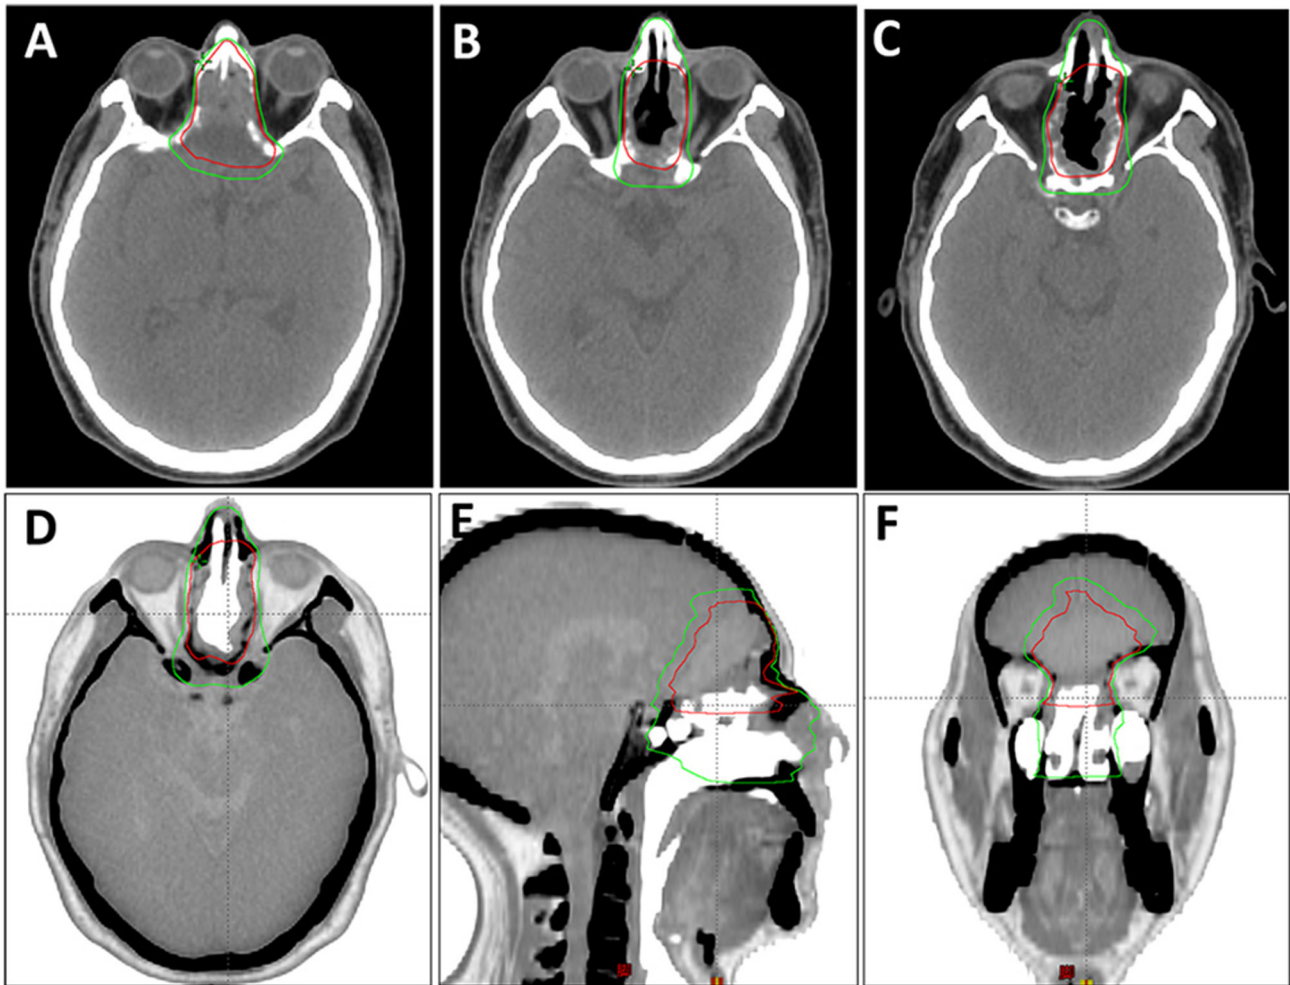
Examples of target volume delineation. (A-C) Target area contours on axial planes at different levels of non-contrast computed tomography images. (D-F) Display of the target contours in (D) axial, (E) sagittal and (F) coronal views. The red outline represents the gross tumor volume of the tumor bed and the green outline represents the clinical target volume 1/high-risk clinical volume.
